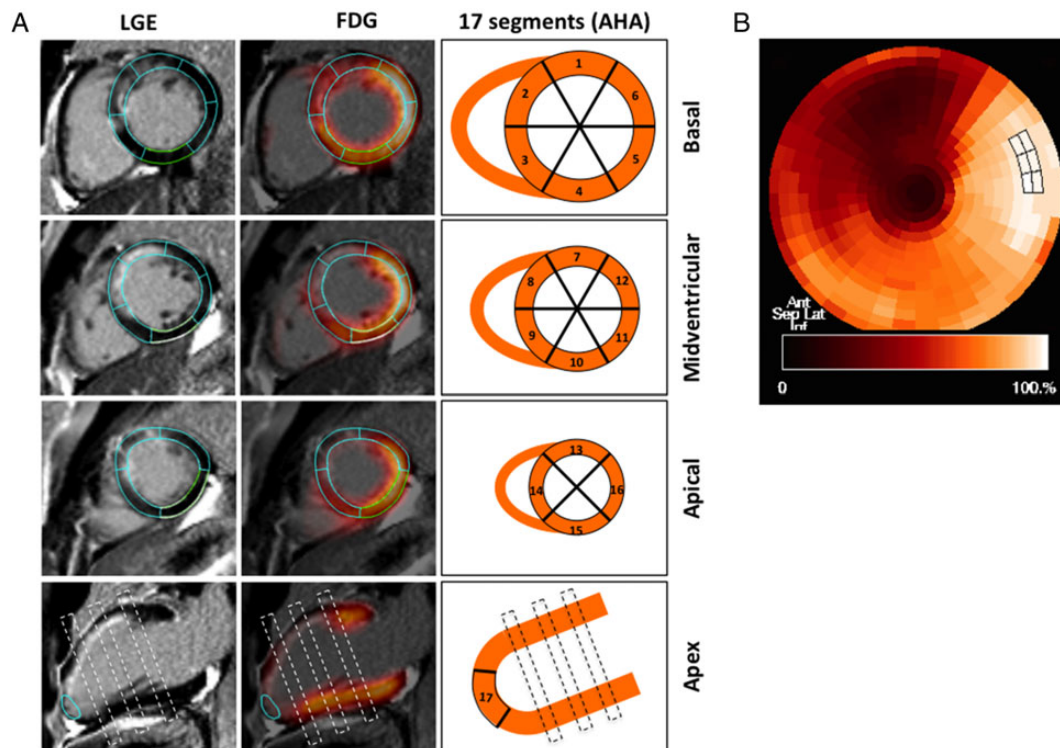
Analysis of segmental FDG uptake and LGE transmural. Segmental FDG uptake and LGE transmural were analysed according to the AHA 17-segment model (A, third column). ROIs were first drawn on a basal, a midventricular, and an apical slice and in the apex in LGE images (A, first column: light blue ROIs in LGE images) and then automatically transferred to identical slices of ideally fused FDG/LGE images (A, second column). LGE in these 17 segments was visually judged as transmural ('MRI non-viable') or non-transmural ('MRI viable') if the LGE transmural proportion was >50 or $\leq 50\%$, respectively. If the FDG uptake in the assessed segment was $\geq 50\%$ or $< 50\%$, respectively, compared with an automatically determined reference ROI encompassing the maximal uptake in the left ventricle, the segment was graded as 'PET viable' or 'PET non-viable' (B, the highlighted six sectors in the static polar map represent the reference ROI set as 100%).
